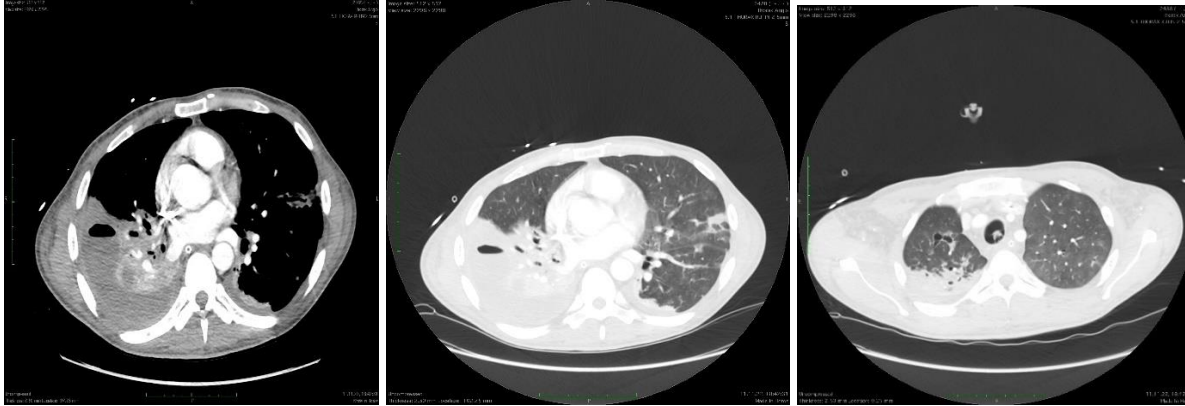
CT scan of the chest. with contrast enhancement.
